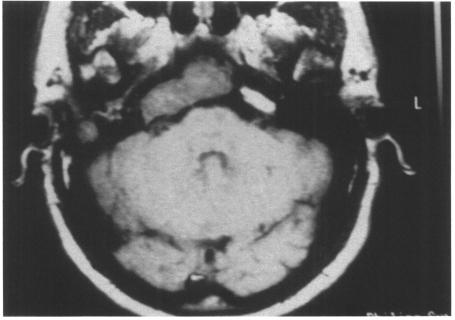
Infralabyrinthine-apical cholesteatoma. MRI demonstrates a large mass reaching the clivus and crossing the midline.
